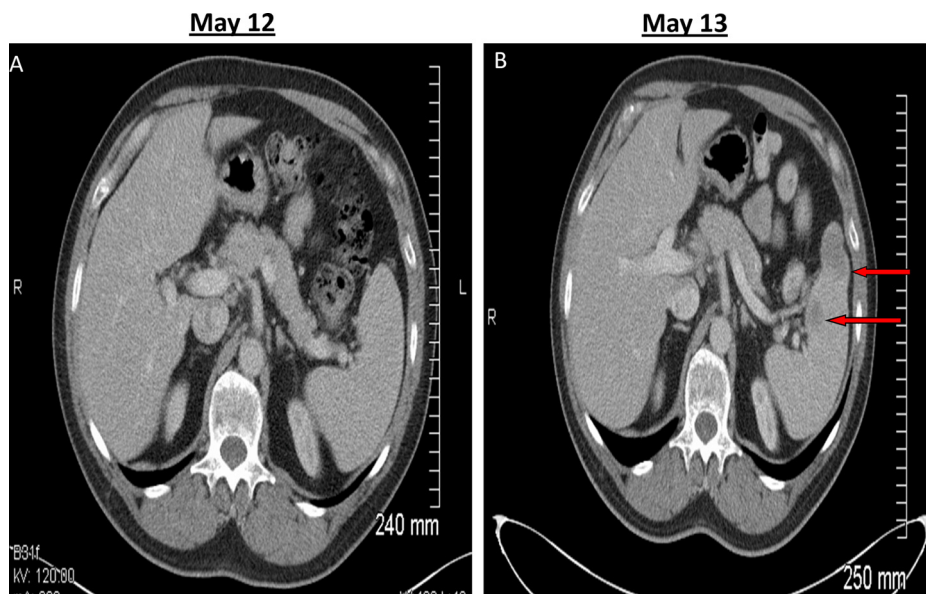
Surveillance CT demonstrating a normal CT in May 2012 and abnormal CT with two splenic lesions 1 year later.
